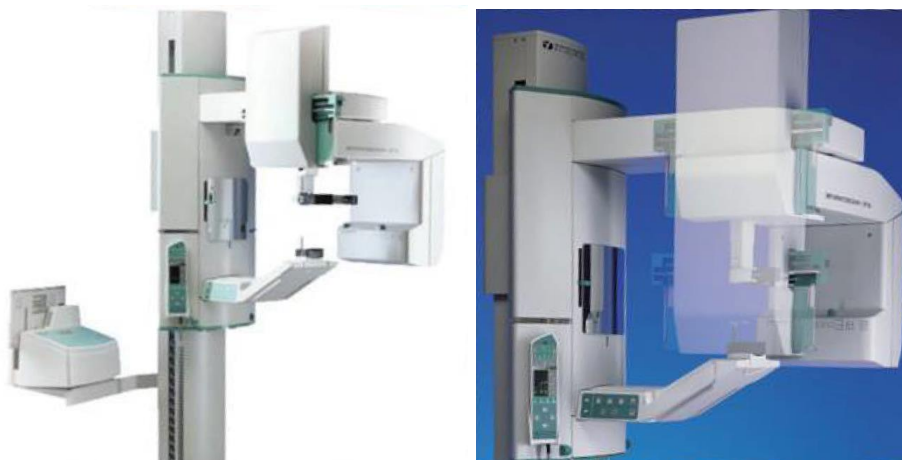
The Orthopantomograph OP100 (1992-2006, Instrumentarium, Tuusula, Finland) implemented automatic exposure control, computed radiology (CR) and linear tomography (OrthoTrans). Courtesy of Instrumentarium Oy and J. Mudrak.
